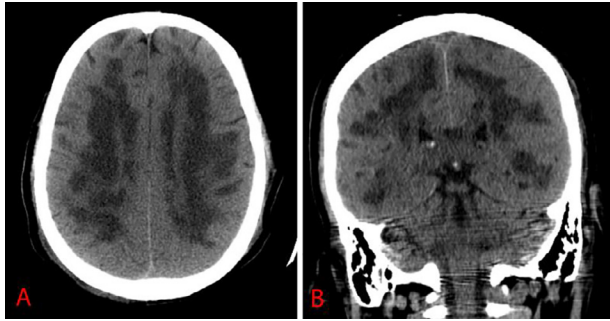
CT scan of brain (first patient). Initial CT in axial (A) and coronal (B) planes show diffuse bilateral white matter hypoattenuation.
